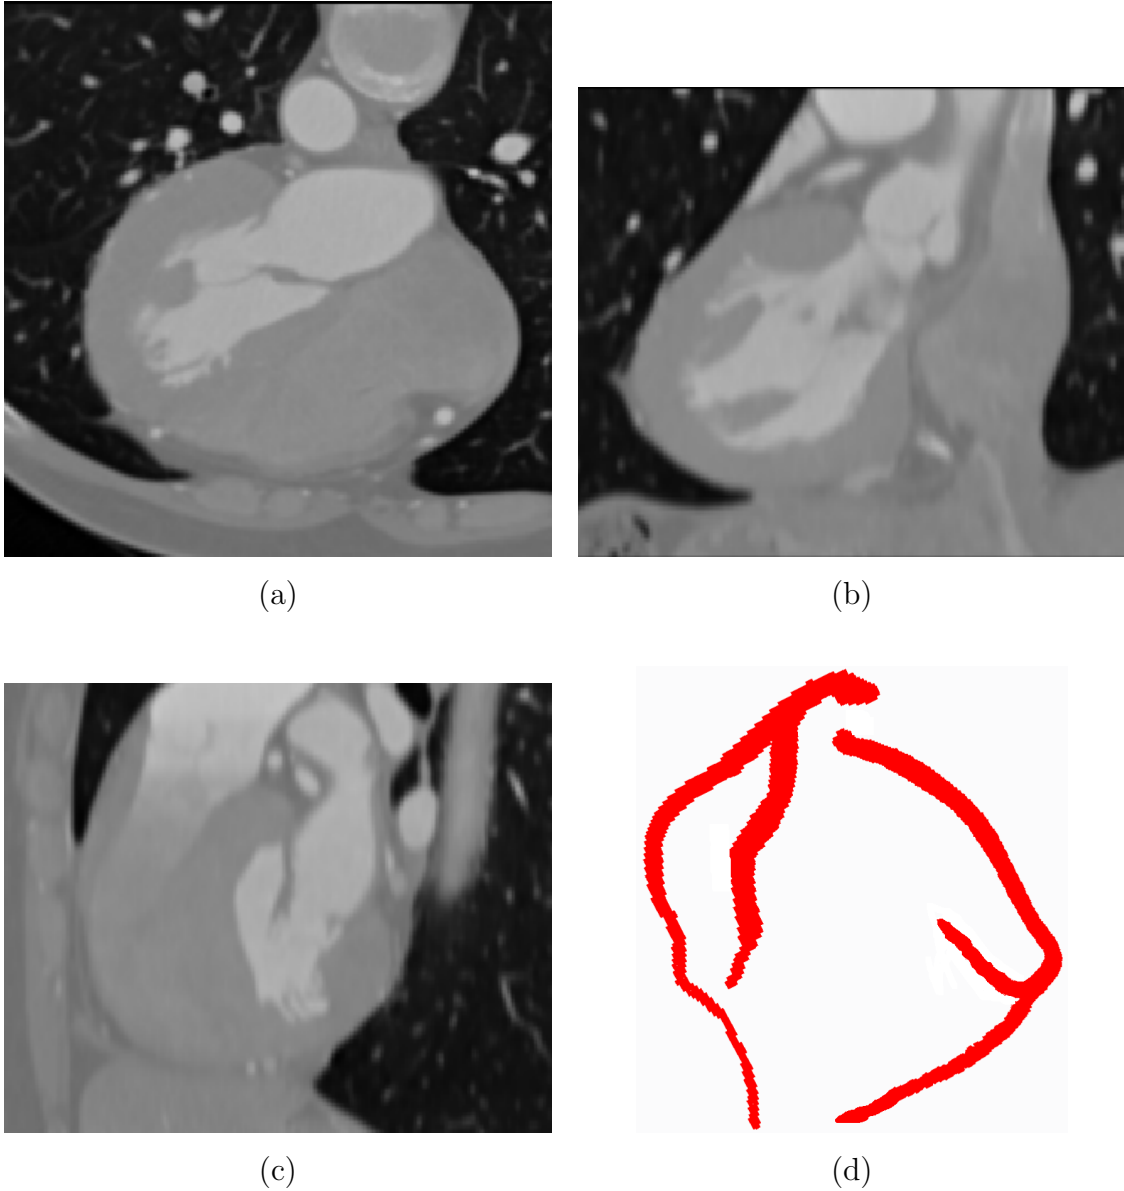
Automatically segmented coronary lumen from the end-diastolic phase of one CTA sequence. (a), (b) and (c): The CTA image is shown in three views. (d): The segmented coronary lumen.
